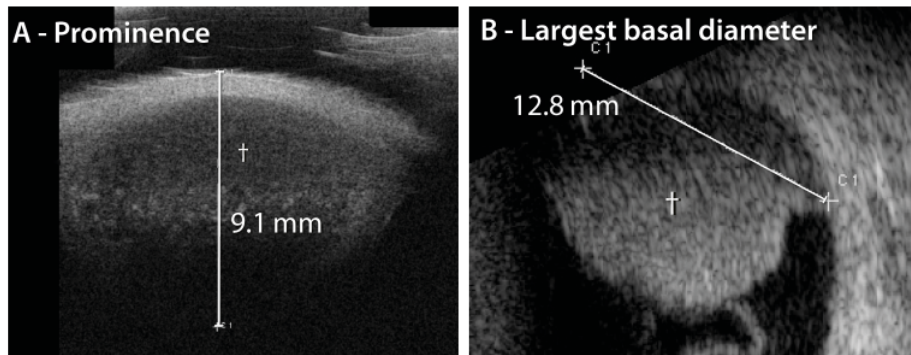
On ocular ultrasound, the full extent of the tumor (dagger) cannot always be visualized due to its limited penetration depth (A) or field of view (B). These measurements were marked as unreliable and analysed separately.
